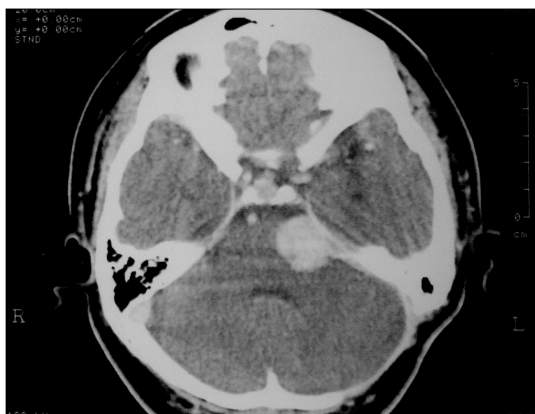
CT scan showing left recurrent large cerebellopontine angle tumor consistent with an acoustic neuroma.
